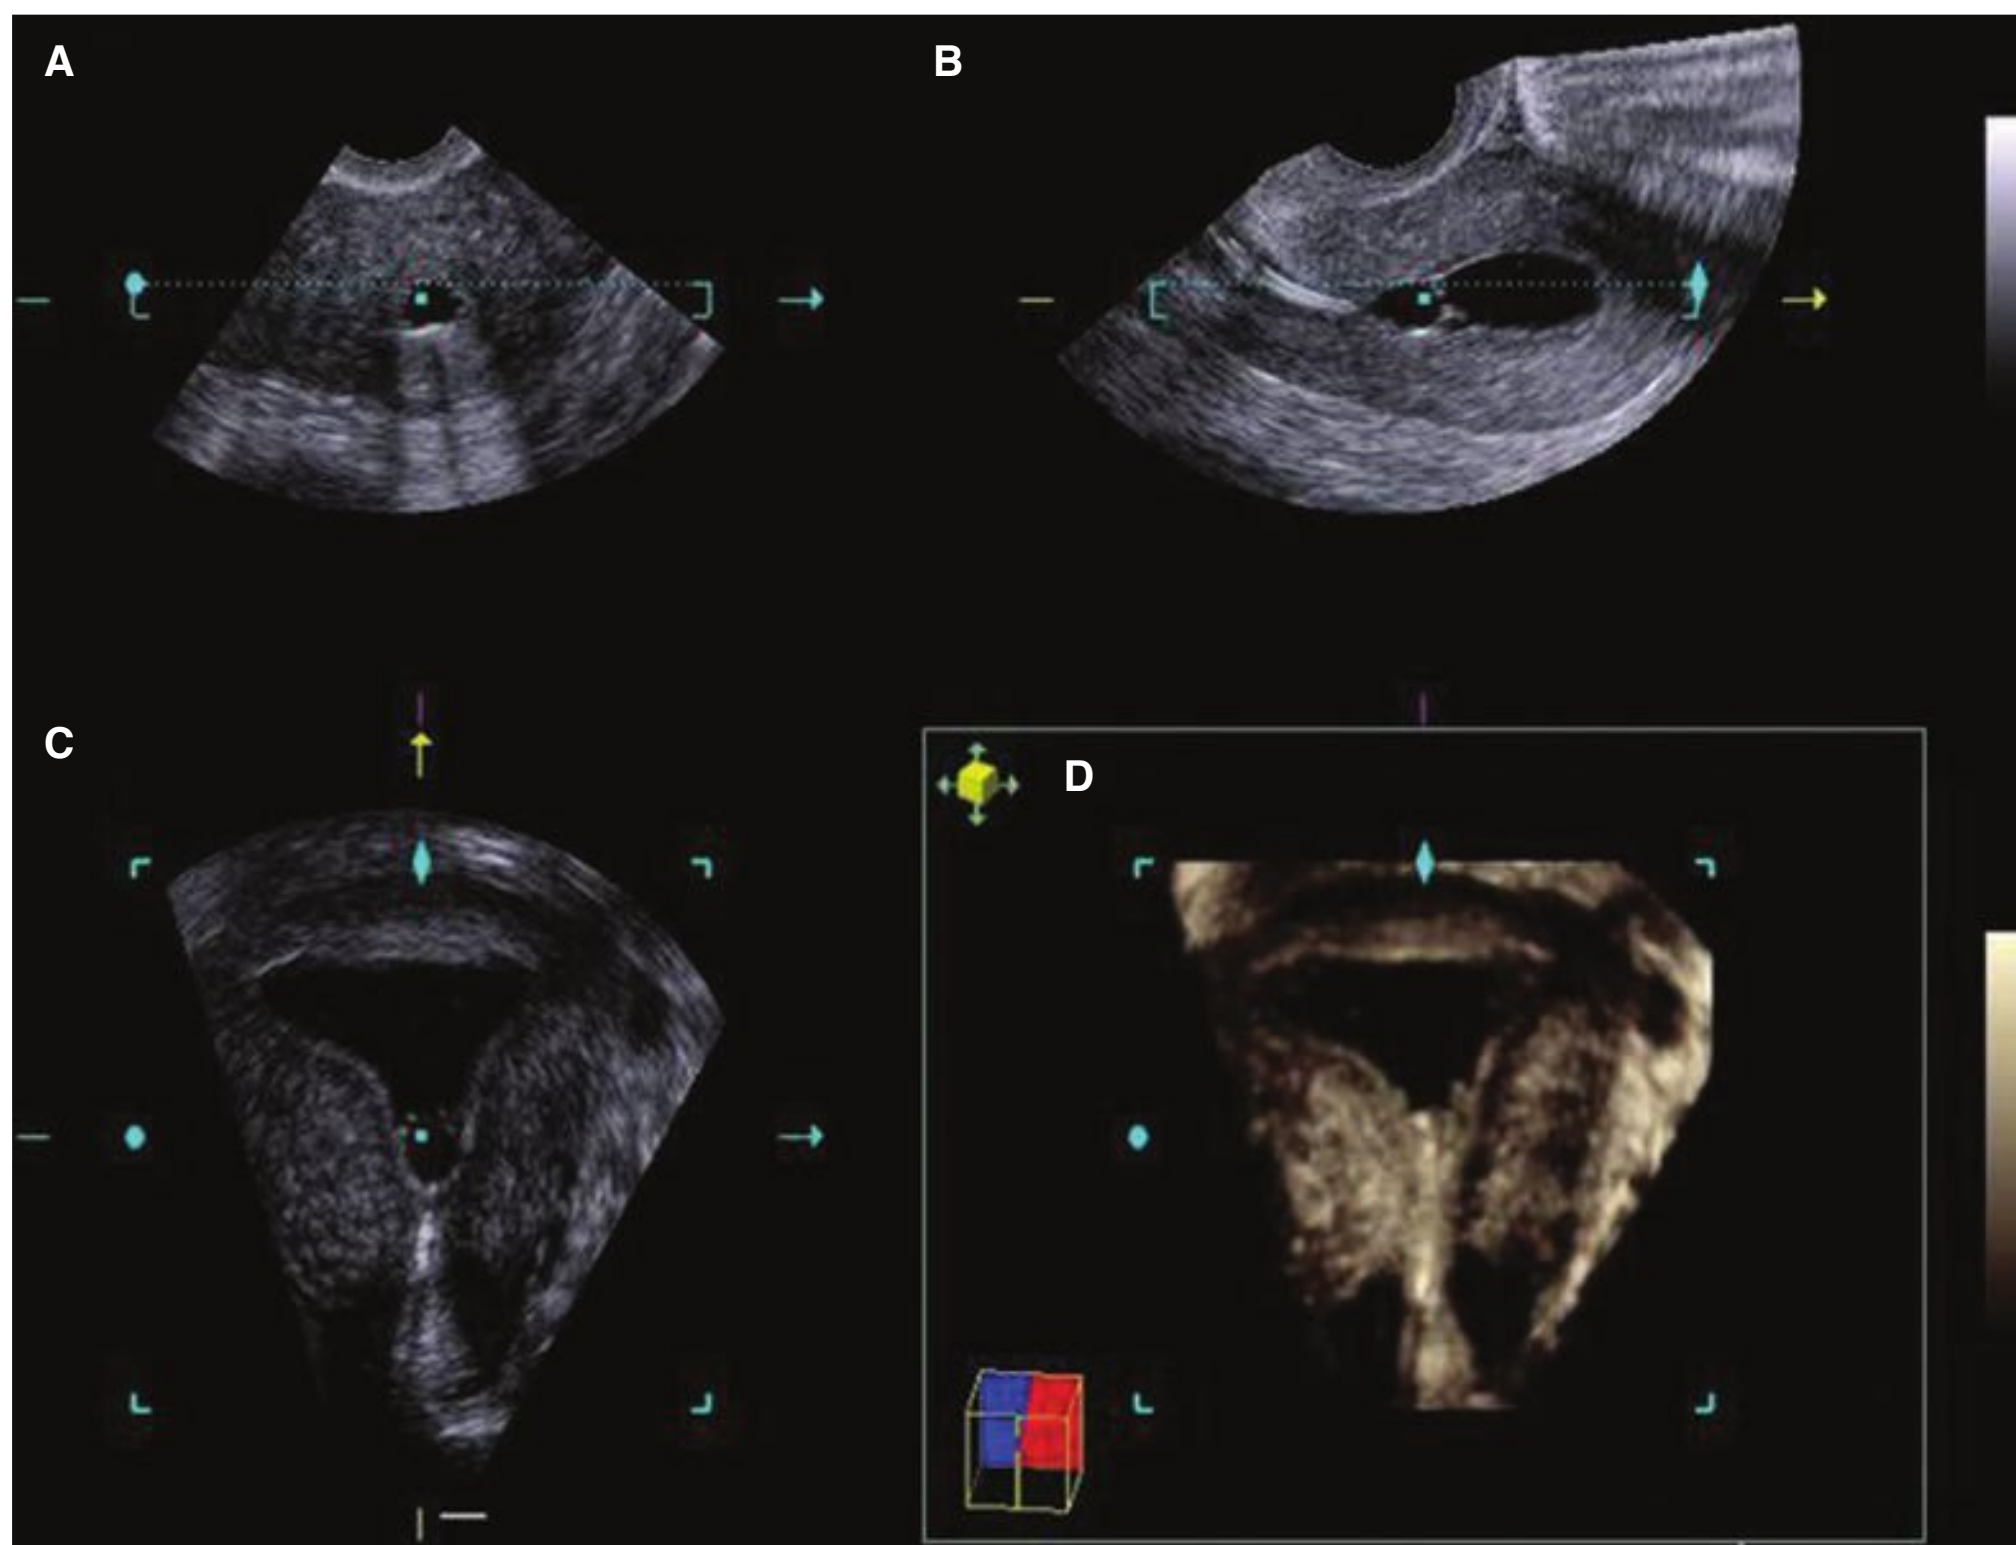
Multiplanar display of a 3-dimensional volume of a uterus and normal endometrial cavity during saline infusion sonography. The views were obtained from a midsagittal reference plane using the Z technique. The planes are as follows: A. transverse, B. sagittal, C. coronal, D. rendered image.
